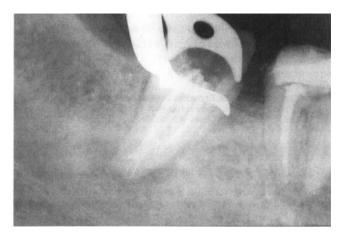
Radiograph after endodontic therapy revealing the presence of communications at different levels between the three main canals and an apical trifurcation.
